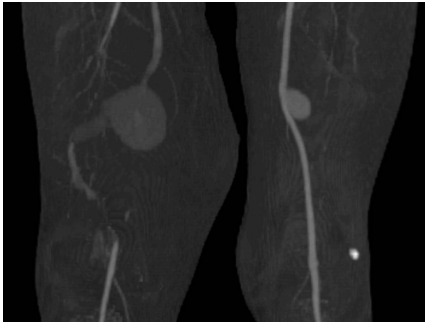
Bilateral superficial artery aneurysms. CTA of a 35-year-old HIV-positive patient who presented with right thigh pain due to a ruptured SFA aneurysm.
